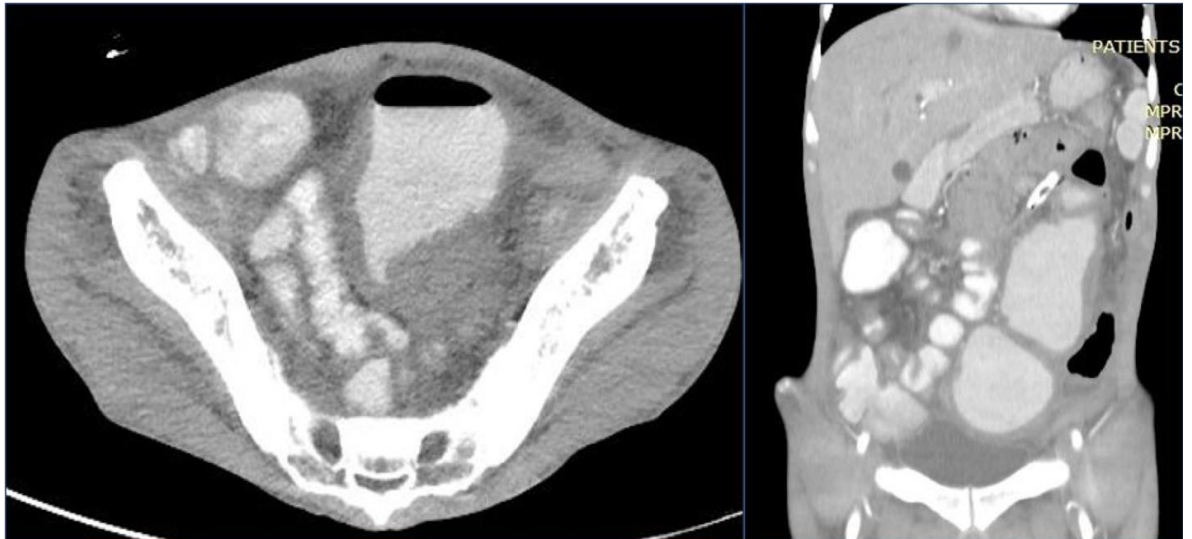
Abdominal CT scan, coronal and axial views showing features of small bowel stricture.
